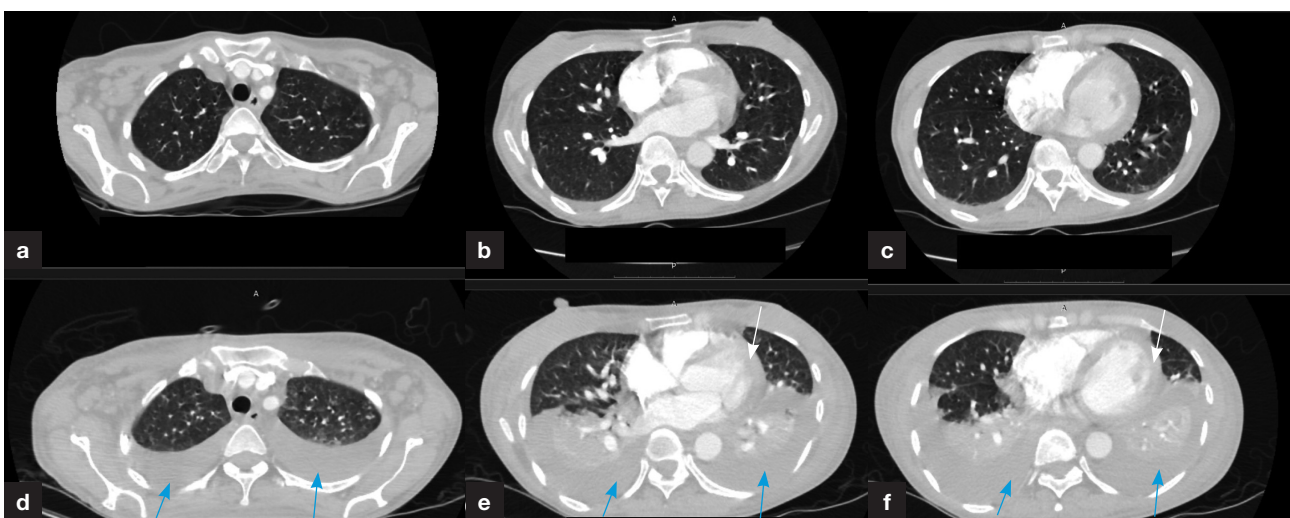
a–c. Three axial views of computed tomography pulmonary angiogram taken on day 0 of starting tuberculosis treatment compared to (d–f) views of the same site showing the extensive bilateral pleural effusion (blue arrows) and pericardial effusion (white arrows) taken on day 7.
